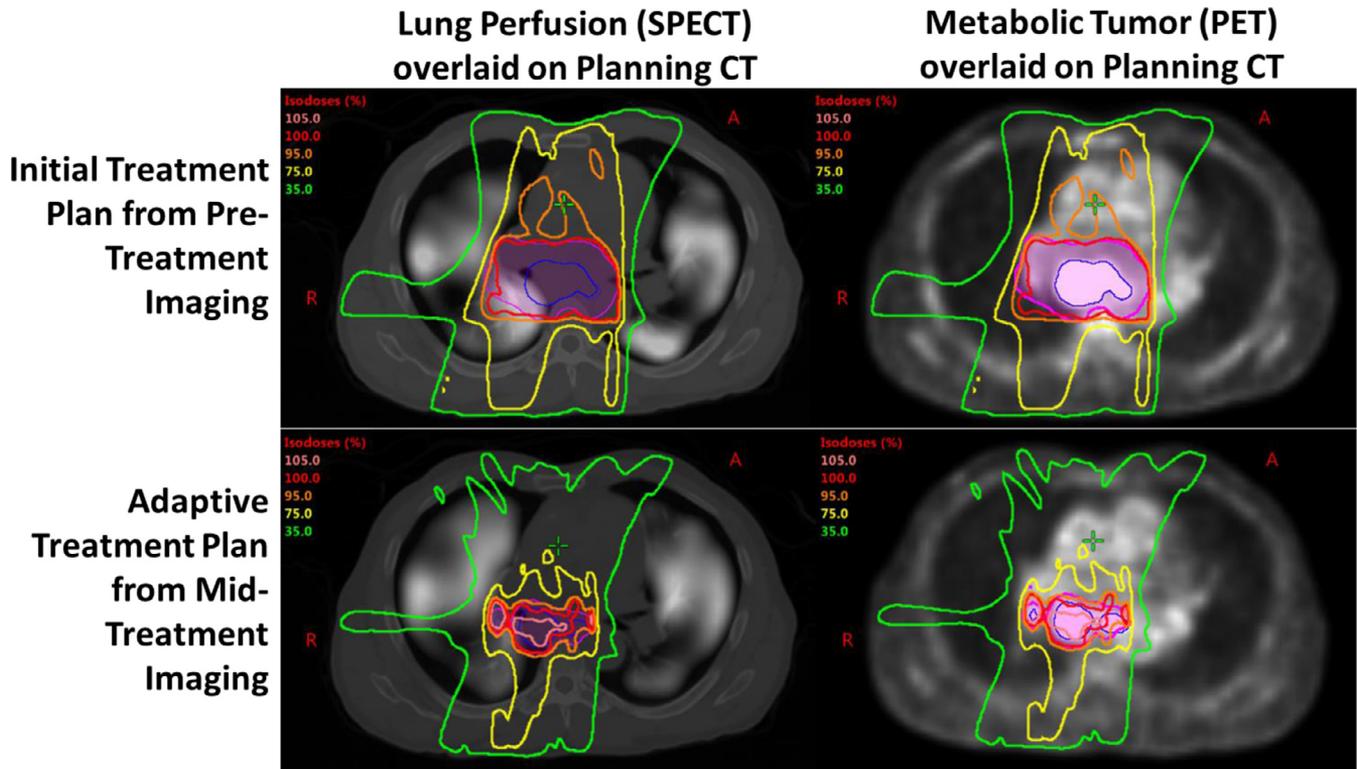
Initial (top row) and adaptive treatment plans for a patient on personalized adaptive trial for advanced stage nonsmall cell lung cancer. Functional target information (FDG-PET, 2nd column) and normal lung function (perfusion SPECT, first column) is used to guide plan optimization for both baseline and adaptive planning.
